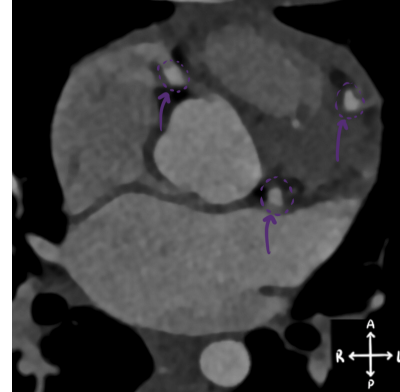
CT scan of the heart of a KD patient. The enlarged coronary arteries are clearly seen (purple circles and arrows). Axial view at the level of the left ventricle outflow.
